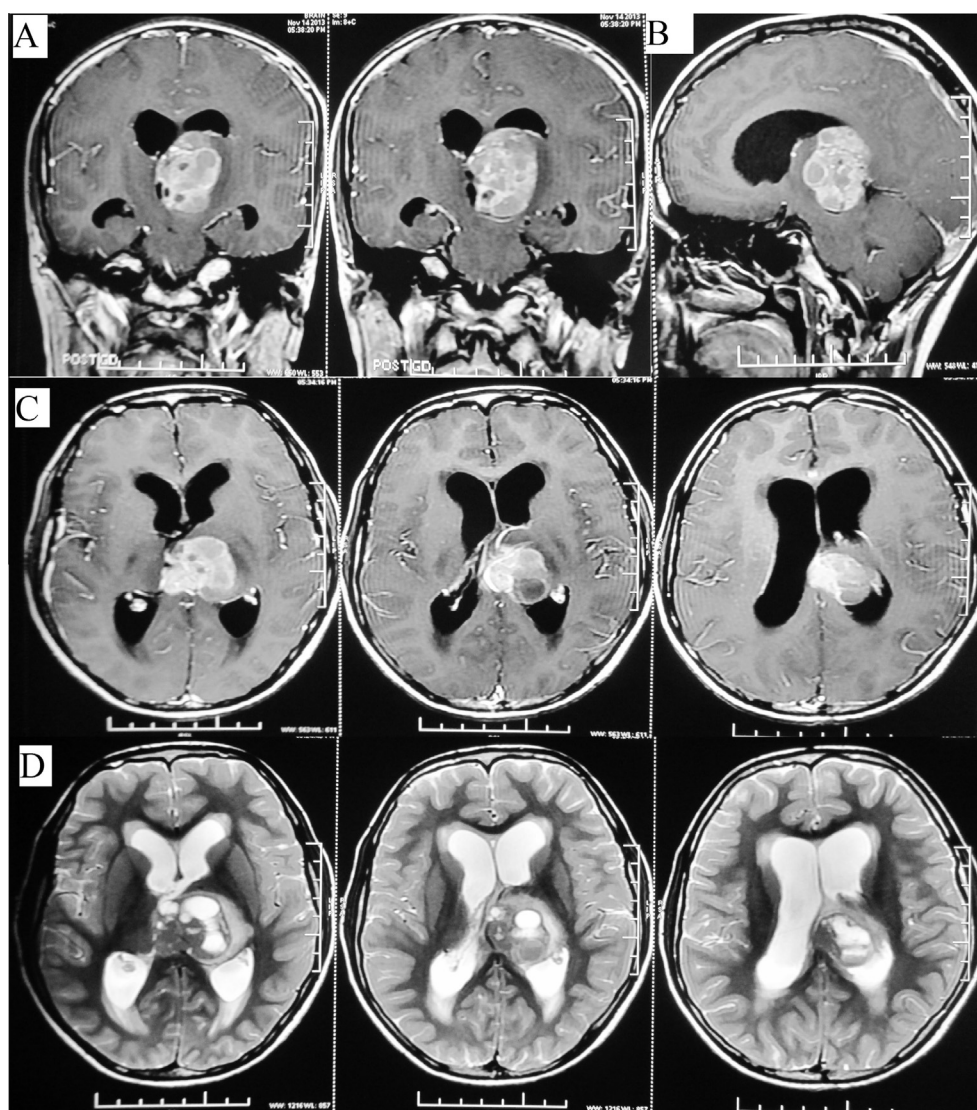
T1 weighted post gadolinium (A) coronal, (B) sagittal and (C) axial MR images of brain show a well-defined, heterogeneously enhancing, solid-cystic lesion in left thalamus, crossing across the mid-line and causing mass effect and dilatation of lateral ventricles. On T2 weighted axial MR images (D), the lesion is heterogeneous with solid and cystic components being iso-intense and hyperintense to grey matter respectively.
